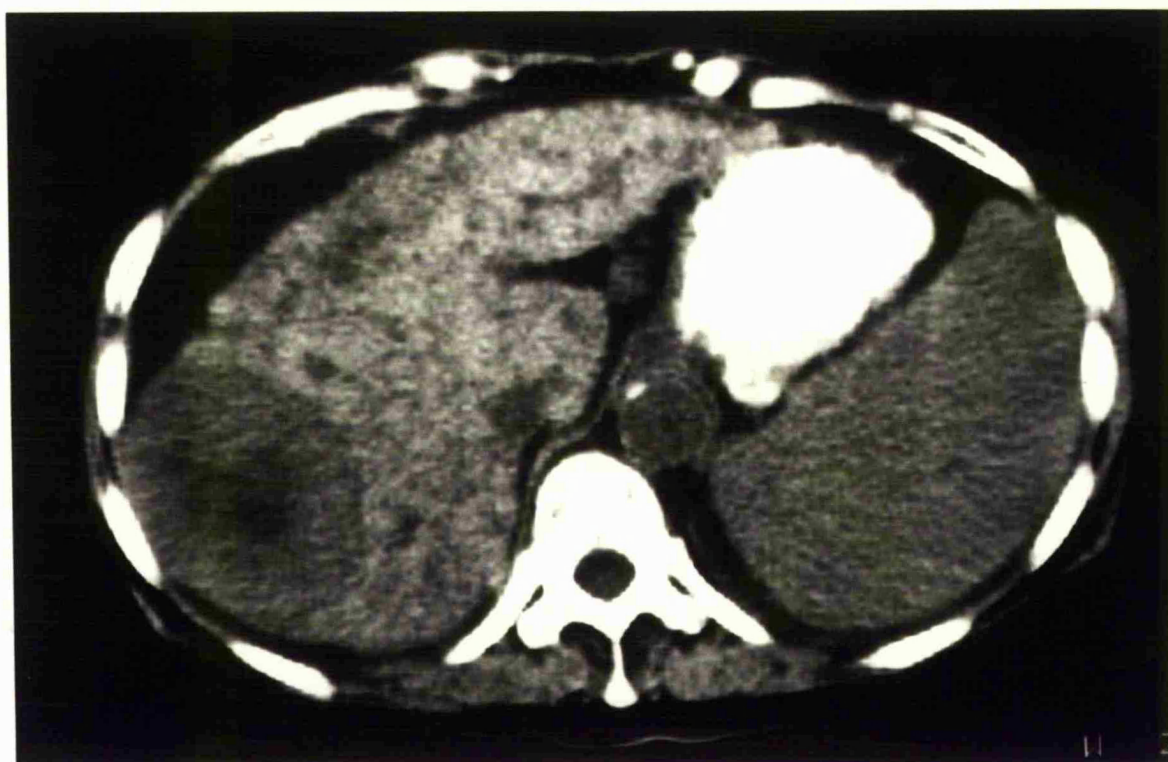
Unenhanced CT from case 2: cirrhosis with hepatocellular carcinoma in the right lobe.
